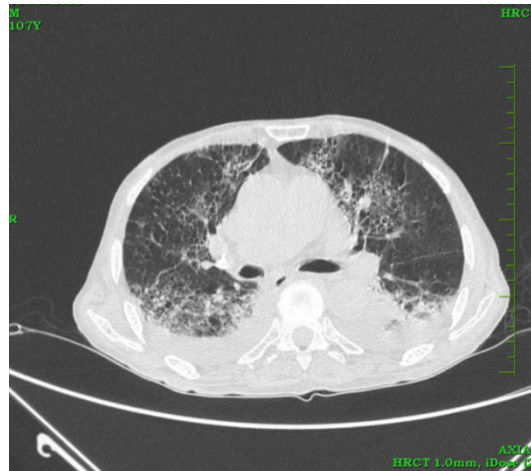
Axial HRCT with crazy paving and pleural effusions.
